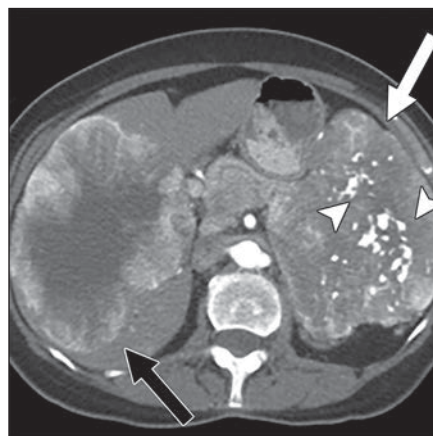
58-year-old woman with alternative lengthening of telomeres (ALT)-positive pancreatic neuroendocrine tumor. Arterial phase contrast-enhanced CT image shows large, necrotic, irregularly shaped mass arising from pancreatic tail (white arrow) with numerous intratumoral calcifications (arrowheads). Large necrotic metastasis has replaced much of right hepatic lobe (black arrow).
